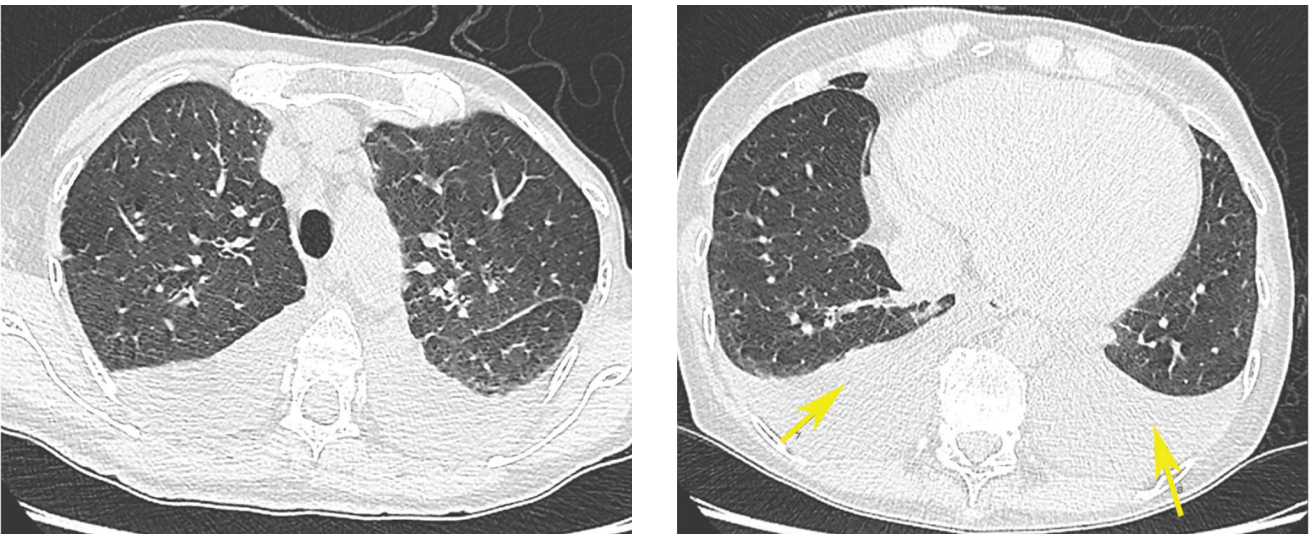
CT scans of 58 y.o. patient with anthracycline cardiomyopathy (cardiomegaly), decompensated heart failure (Kerley lines) and confirmed COVID-19 pneumonia (ground glass opacities) at admission
